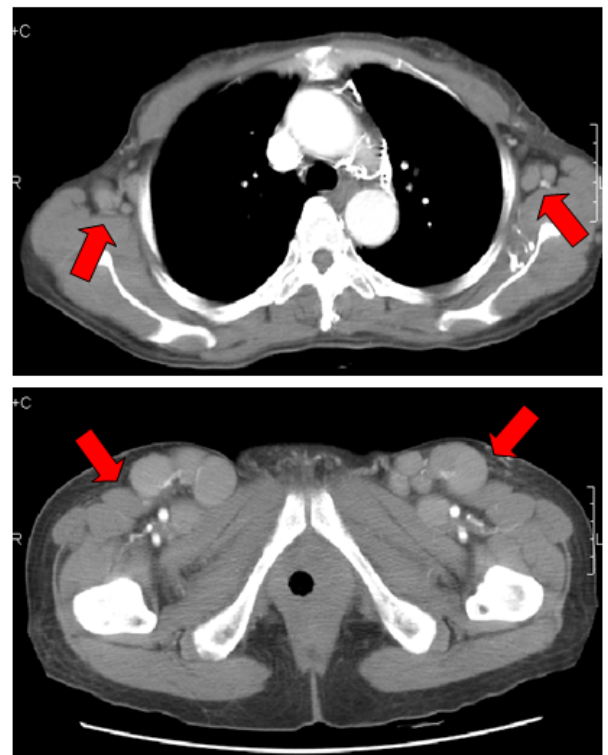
Images of CT scan showing enlarged axillary and inguinal lymph nodes during the treatment.
